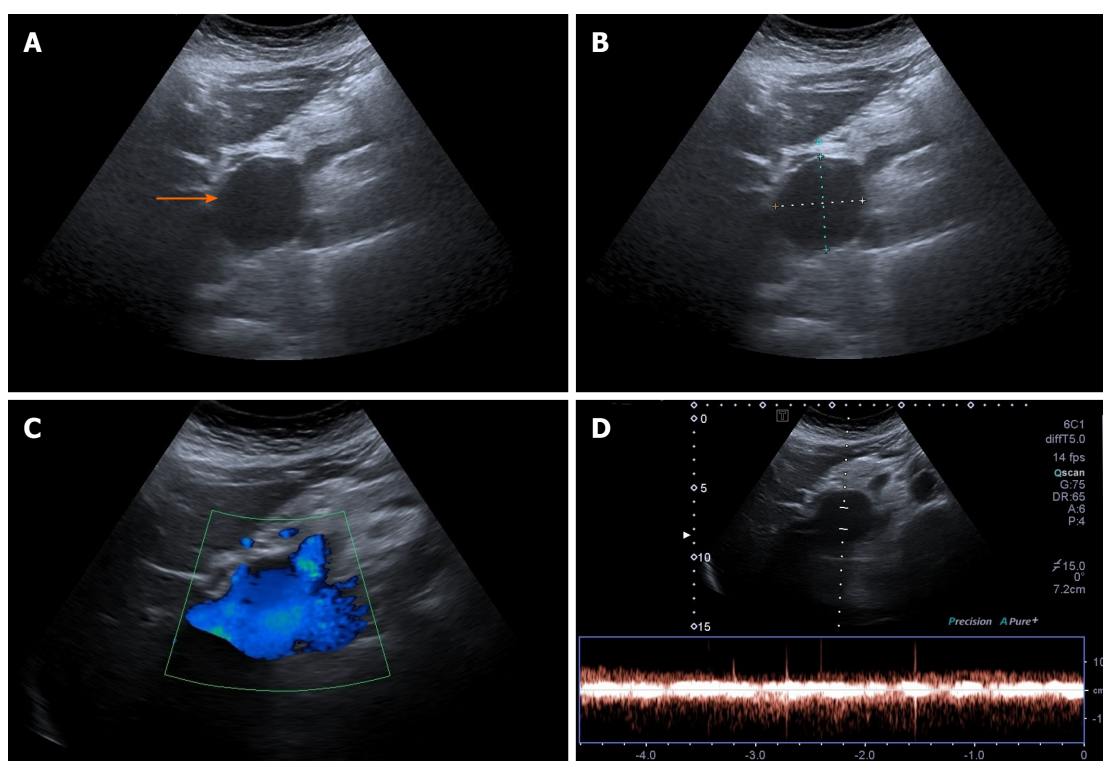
Abdominal ultrasonographic imaging of Case 2. A: Extrahepatic anechoic saccular lesion, indicating an aneurysmal dilation of the extrahepatic portal vein (arrow); B: The anechoic lesion was 42.3 mm at its maximal diameter; C: Colour Doppler showed hepatopetal venous flow in the extrahepatic aneurysmal dilated vessel; D: Doppler recording showed pulsating flow of venous type.
